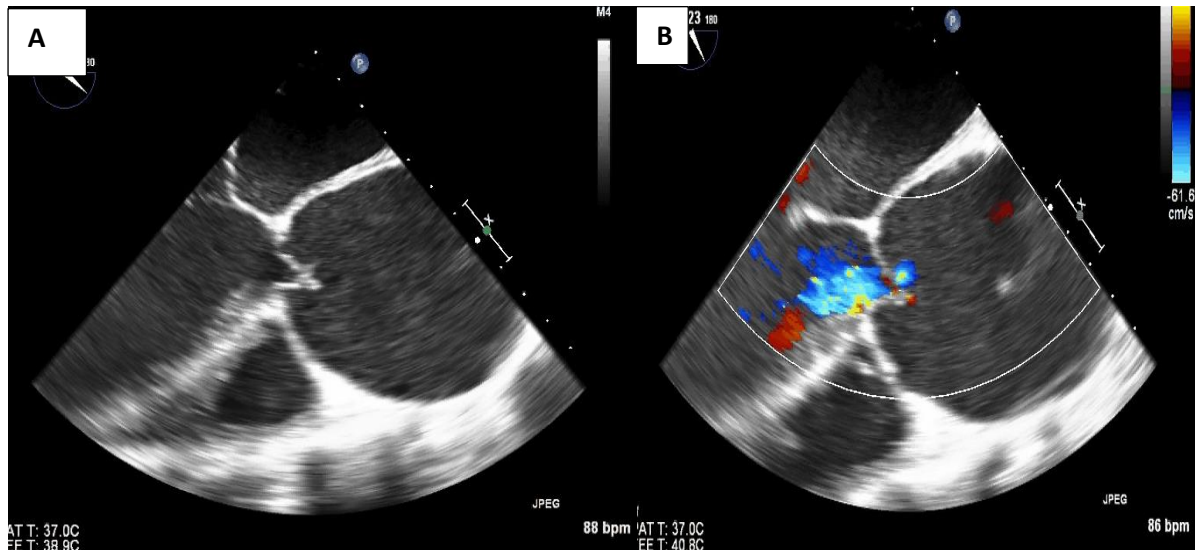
(A) Echocardiographic long axis views showing a large aneurysm of the ascending aorta (B) complicated by severe aortic regurgitation secondary to aortic root dilation.
